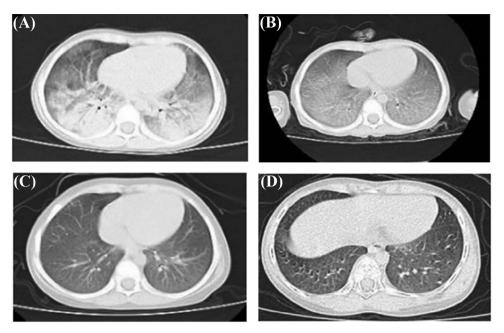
The manifestations of chest HRCT in the two patients with lysinuric protein intolerance. (A) Patient 1, before admission, chest HRCT showed diffuse grid-like shadows and ground-glass opacity shadows in both lungs and large areas of consolidation in the dorsal lung segments. (B) Patient 1, after immunotherapy, consolidations in both lungs were absorbed, but diffuse interstitial lesions worsened. (C) Two months post-discharge, after total diet therapy and alveolar lavage, bilateral diffuse grid-like shadows significantly improved for Patient 1. (D) Patient 2's initial chest HRCT showed decreased transmittance in bilateral lower lungs and faint dot shadow. HRCT, high-resolution computed tomography.
